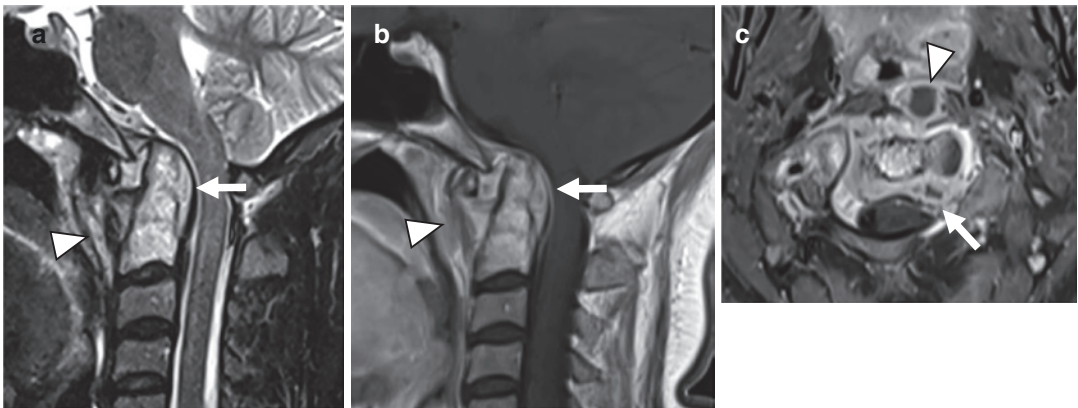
Craniocervical junction tuberculosis. Sagittal (a) T2-W and (b) contrast-enhanced T1-W and (c) axial contrast-enhanced fat-suppressed T1-W MR images show signal hyperintensity of C1 and C2 vertebral bodies with epidural (arrows) and paravertebral (arrowheads) extension
